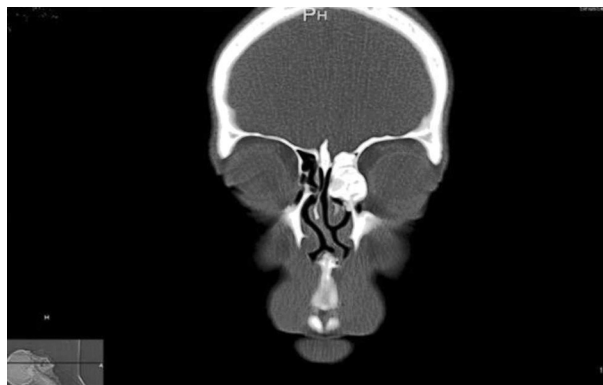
Coronal plane paranasal sinus computerized tomography (CT) showed a 4x3 cm calcified mass consistent with osteoma which occupied left ethmoid cellulae and frontal recess, compressed and eroded the left lamina papyracea, invading orbital wall in the vicinity of middle skull base.
